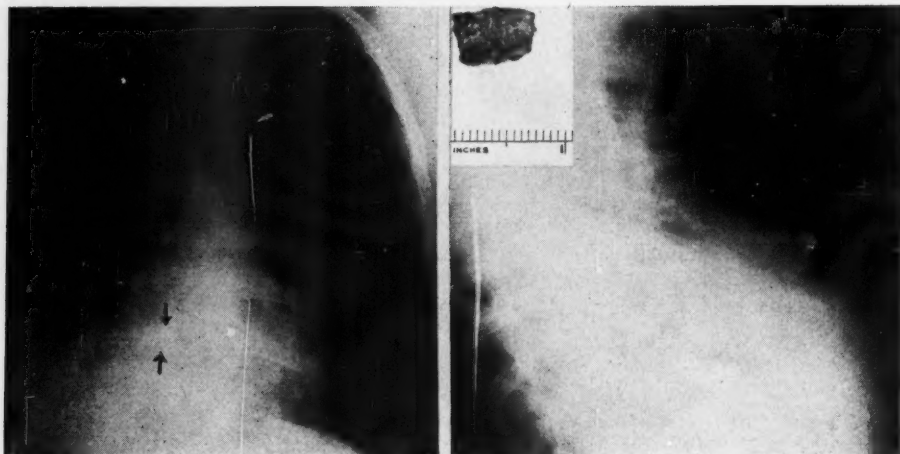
Case 13: Foreign body within pericardium, lying between the aorta and right auricle. The roentgenogram was interpreted as showing the foreign body in the lung. Fluoroscopy would have disclosed movement of fragment with each heart beat, thus locating it within the pericardium or within the heart.
